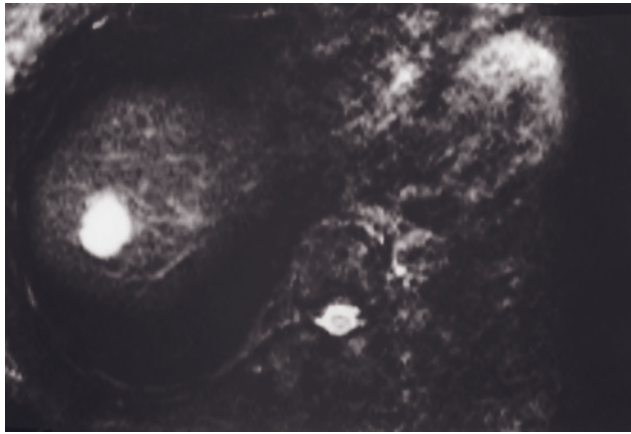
(Continued) low signal intensity on T1-weighted image (not shown) and enhances in a peripheral nodular fashion on early image (f), which fills in on late image (g).
